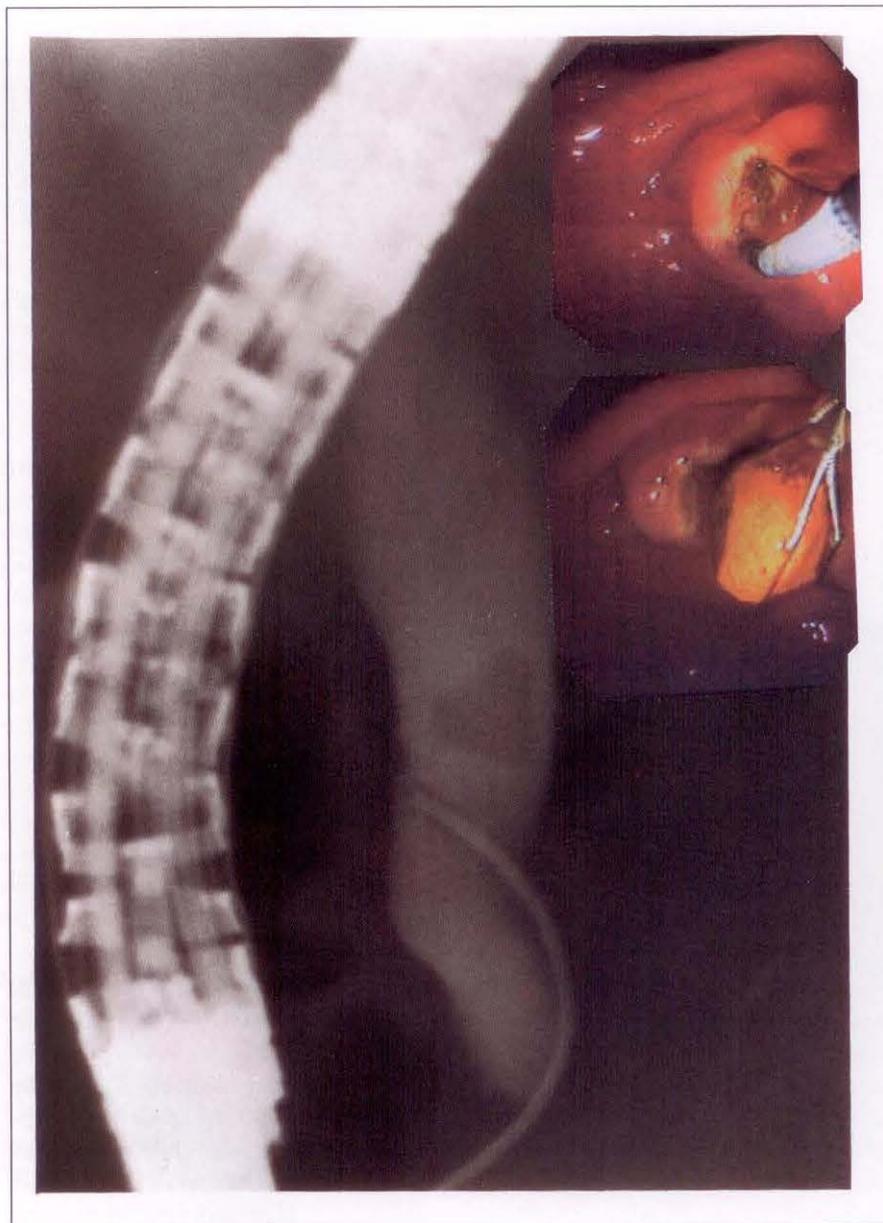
Radiograph demonstrates excessive wire in biliary tree. Inserts demonstrate wire retrieval prior to sphincter section and calculus retrieval
